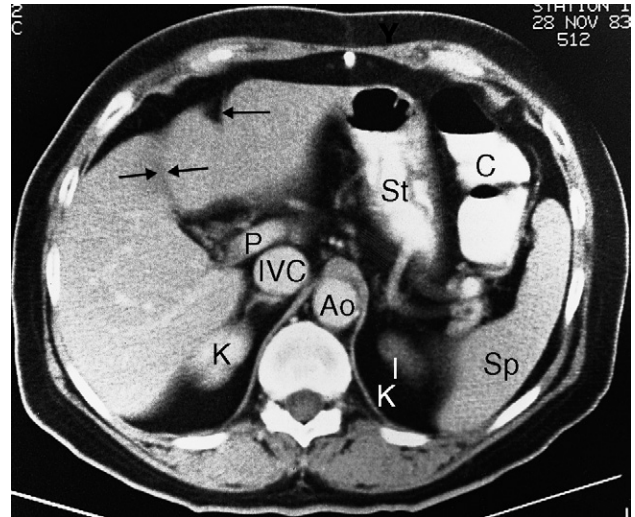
CT scan of normal liver through the porta hepatis (enhanced scan). Ao, aorta; C, colon; IVC, inferior vena cava; K, kidney; P, portal vein; Sp, spleen; St, stomach. The single arrow indicates a fissure for the falciform ligament, and the double arrows a fissure for the gall bladder, which divides the liver into the right and left lobes.
